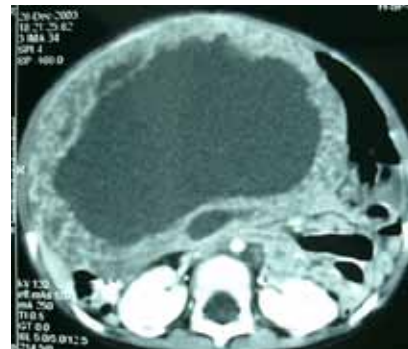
CT scan of hepatoblastoma.
